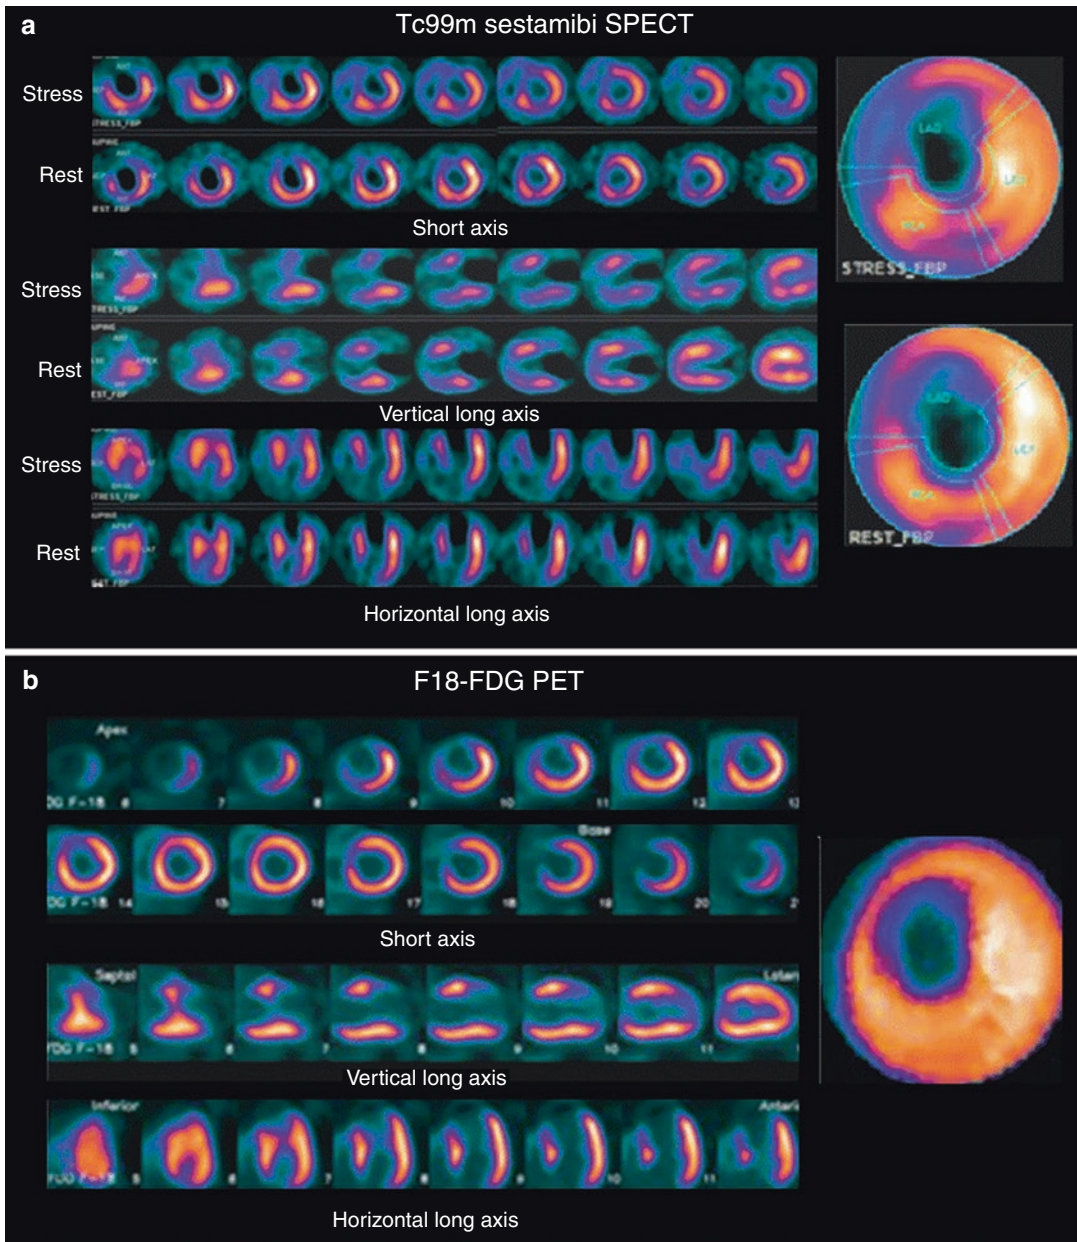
Tc-99m sestamibi stress and rest myocardial perfusion SPECT images and polar maps (a) and F-18 FDG studies (b) for a 62-year-old male with dyslipidemia, smoking, and fixed perfusion defect on myocardial perfusion SPECT. The patient was referred for viability study. Tc-99m sestamibi SPECT images (a) demonstrate a large
